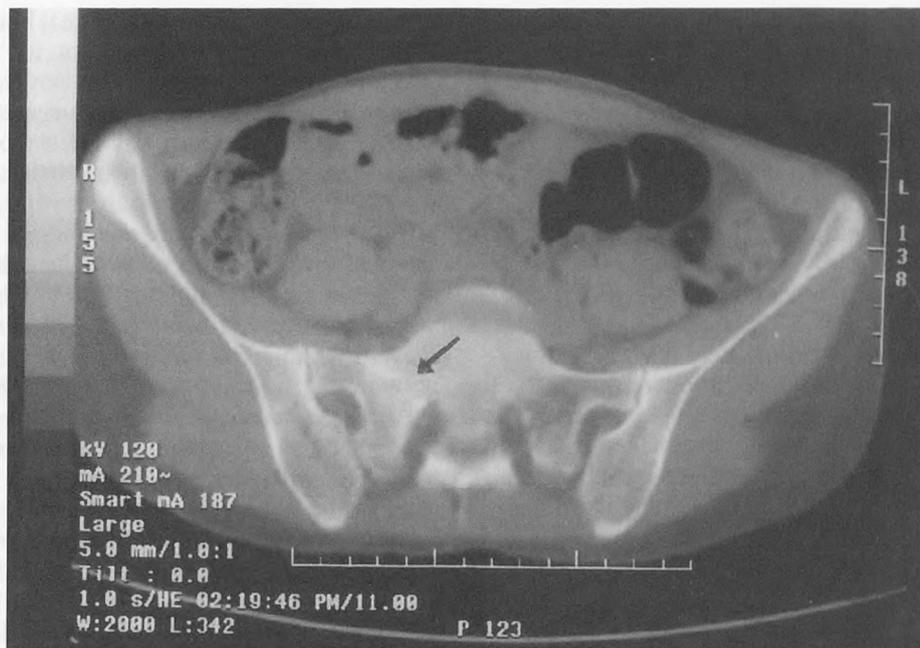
Computed tomography scan revealing abnormal sclerosis in the right sacral ala (5 weeks after onset of symptoms).
